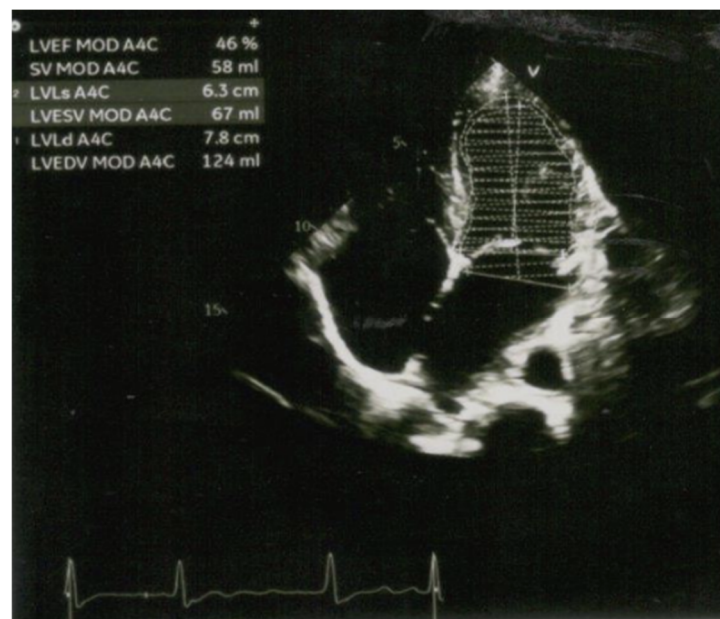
Echocardiography at the second day of hospital stay showing segmental wall motion abnormality with EF 48% (Simpson 46%).
